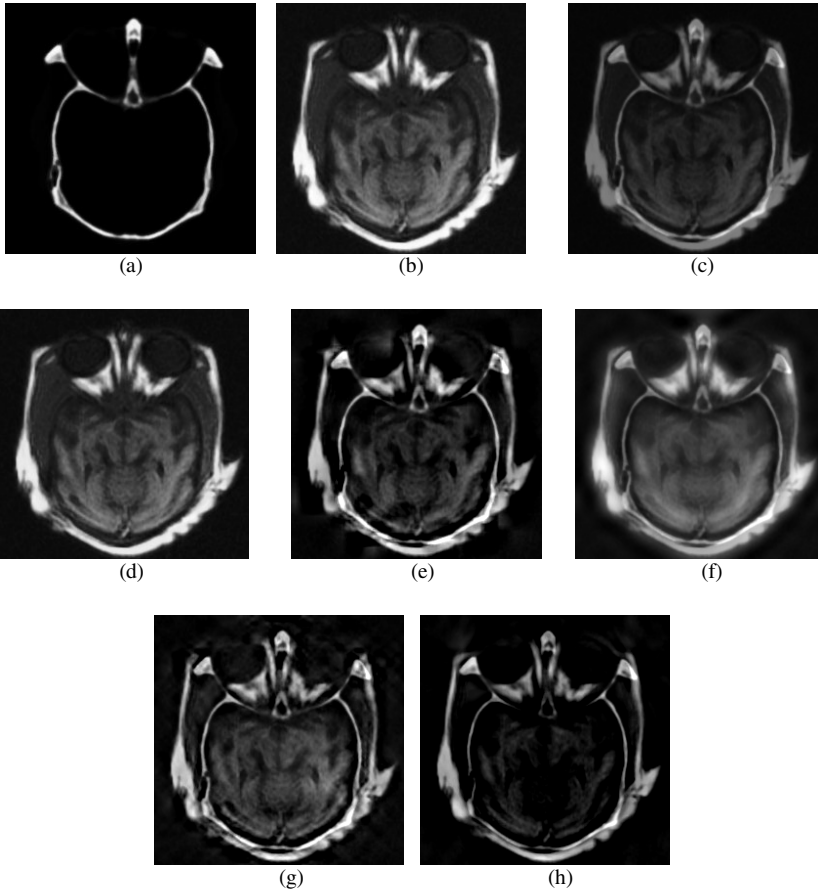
Test CT/MR images fused results with different method. (a) CT image. (b) MR image. (c) Average method. (d) PCA. (e) Wavelet. (f) Curvelet. (g) Contourlet. (h) Proposed method.
